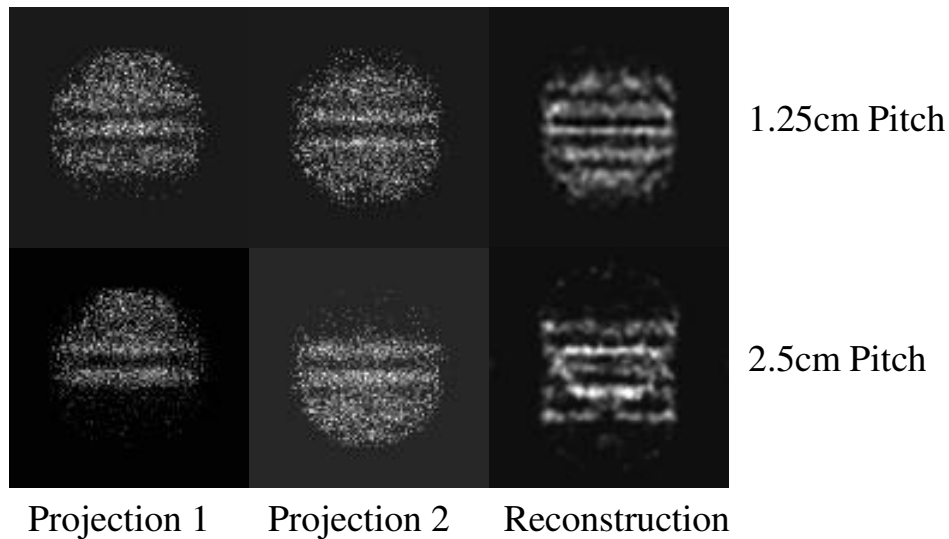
Sample images from both projection sets along with reconstructed images are shown for experimental data from the MicroSPECT system. The images from the 2.5cm pitch show a severe artifact in the center of the image due to differences in sampling caused from the circular FOV. The artifact is present in the 1.25cm pitch image, but not as severe. This would indicate that for circular cameras, the optimal pitch is less than the pitch that can be used for square cameras.
